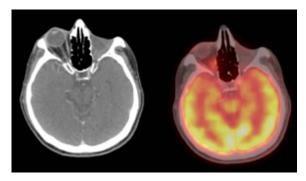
CT and fusion PET-CT image showing no evidence of abnormal metabolic activity in left orbit (post surgery site). The FNAC of this region revealed no evidence of residual/ recurrent disease.
